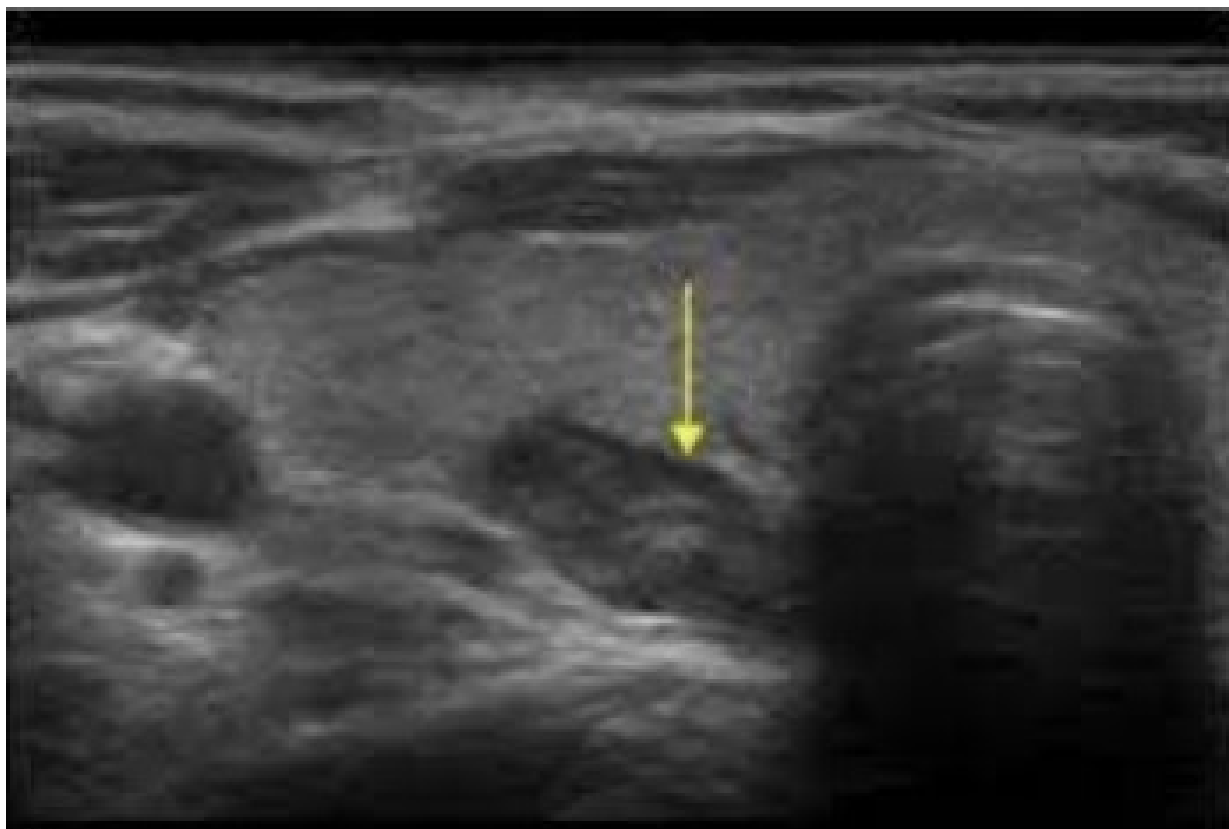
High resolution ultrasound showing the typical appearance of a parathyroid adenoma. The yellow arrow indicates an ovoid parathyroid lesion posterior to the thyroid gland.
